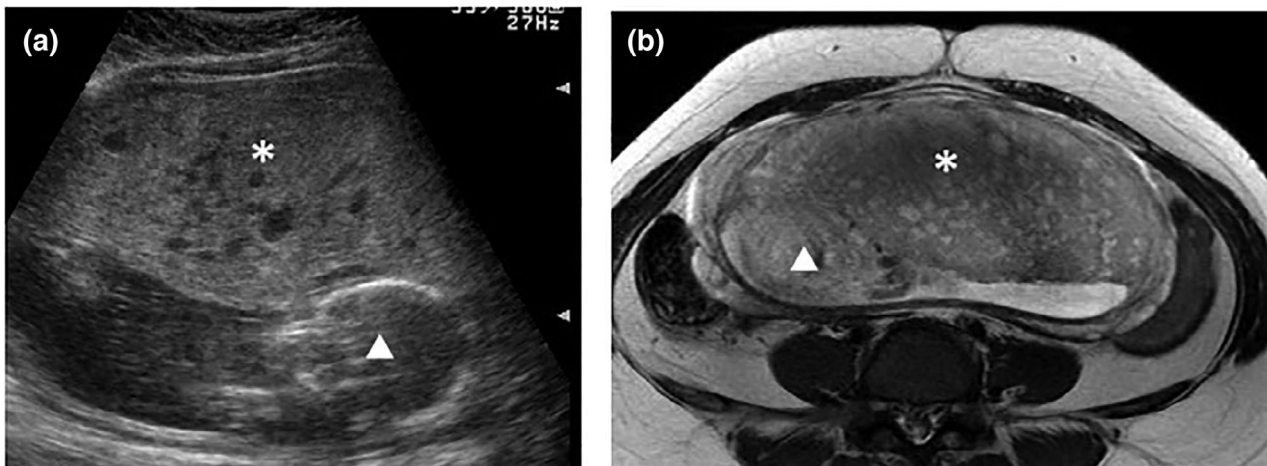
Typical prenatal imaging in PMD. (a) Ultrasonography showed a thickened chorionic plate (asterisk) with a multicystic lesion and living fetus (arrowhead) (17 weeks and 5 days of pregnancy, at our institution). (b) T2-weighted magnetic resonance imaging revealed multiple high-intensity cystic lesions in the placenta (asterisk) and fetus (arrowhead) (18 weeks and 0 days of pregnancy, at our institution)
